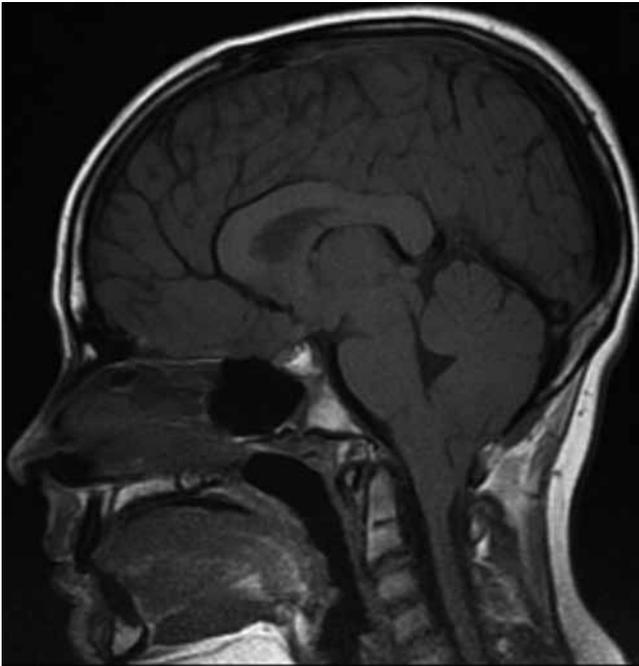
Preoperative MR imaging showing Chiari I malformation.
